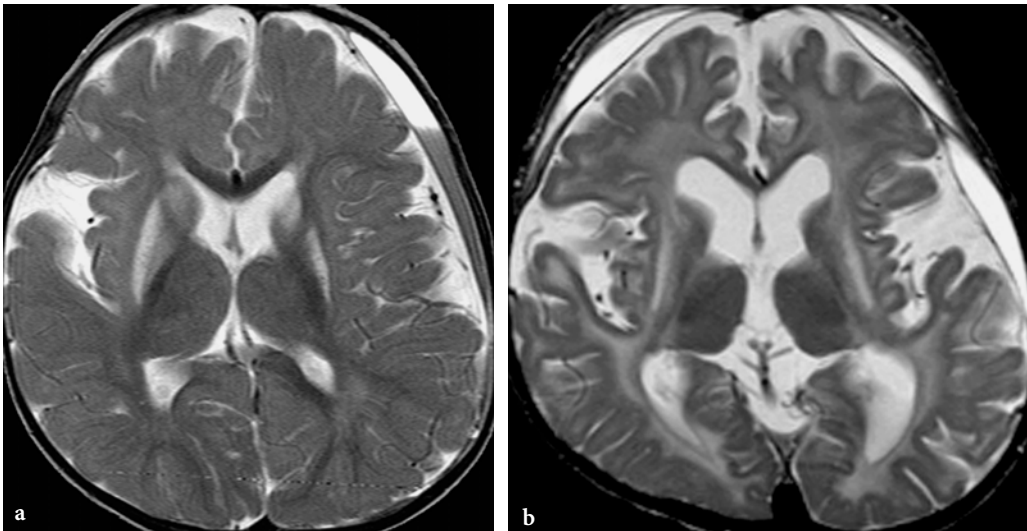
Chronic subdural hematomas in patients with glutaric aciduria type 1. Axial T2-weighted fast spin-echo images. a 3-year-old macrocephalic female patient. Left-sided fronto-temporal subacute subdural hematoma without history of head trauma. Bilateral basal ganglia disease and open Sylvian fissure on the right side. b 2-year-old male patient. Multicompartmented chronic subdural fluid collections bilaterally. The patient had several surgical interventions in the past for subdural hematomas. Bilateral basal ganglia signal abnormalities. Extensive white matter hyperintensities in conjunction with diffuse brain atrophy
